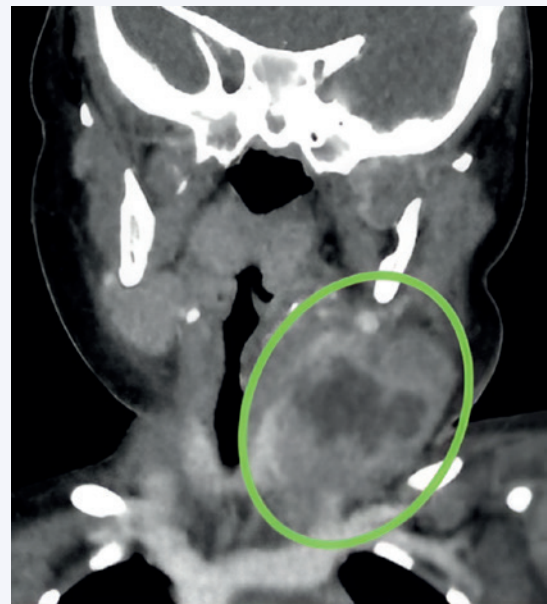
AND 3: CT scan of neck. On the left side confirmation of thrombosis of the internal jugular vein. On the right side unilaterally enlarged lymphadenopathy (1.7 x 1.7 x 1.2cm) with possible abscess.
